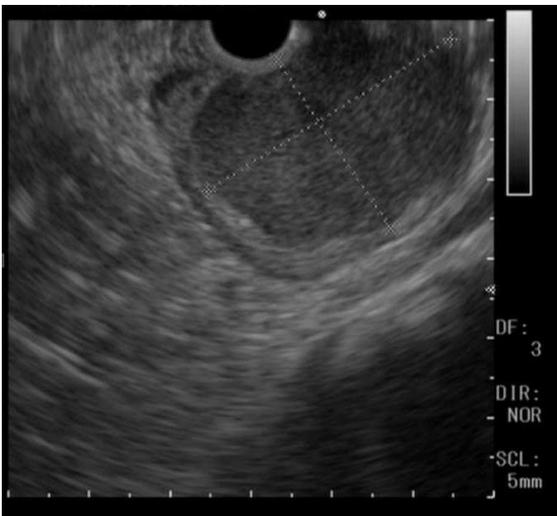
Findings on upper endoscopic ultrasonography.
